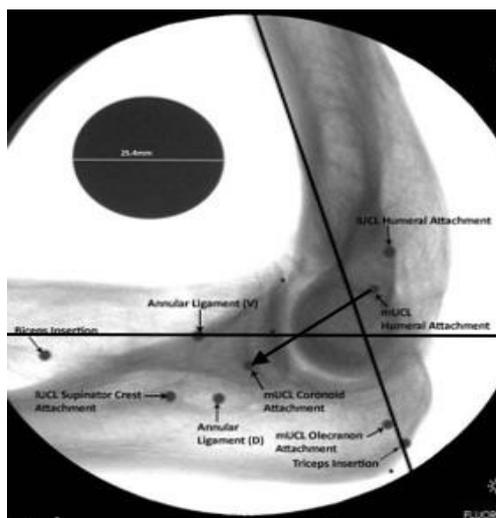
Lateral radiograph image demonstrating example measurement. The anterior humeral line and the mid-axial radial line are present. Asterisks denote osseous landmarks: coronoid tip, the center of the radial head, and olecranon tip. D: dorsal attachment; V: volar attachment; MUCL: medial ulnar collateral ligament; LUCL: lateral ulnar collateral ligament
